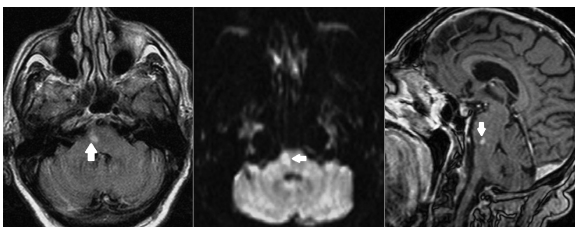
Magnetic resonance imaging (MRI) nine days post coronary catheterization. Left: Axial brain MRI image (fluid attenuation inversion recovery sequence) demonstrating a high-intensity signal lesion in the right pons, consistent with infarction. Middle: Axial brain MRI image (diffusion weighted imaging sequence) demonstrating a high-intensity signal lesion with a luxury perfusion in the right pons, consistent with a subacute ischemic infarction. Right: Sagittal brain MRI image (T1+Contrast sequence) demonstrating a high-intensity signal lesion in the right pons, consistent with infarction.
